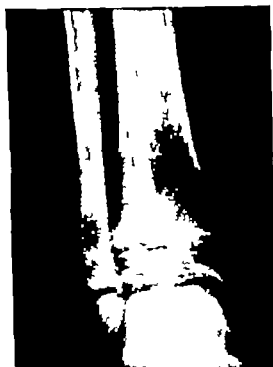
Another typical fibroma, although small. This one was found incidentally on roentgenographic study of the ankle of an 8-year-old girl.
